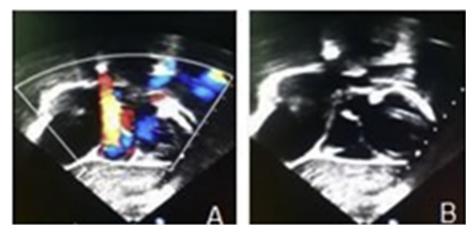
Transthoracic echocardiography showing echogenic mass collected at the right side of the heart (A, B).
